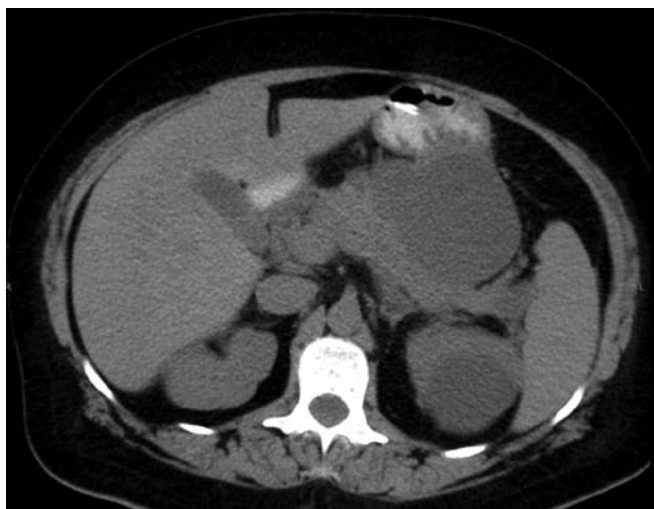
An abdominal computed tomography scan showing a lesion suggesting a pancreatic pseudocyst compressing the stomach.
